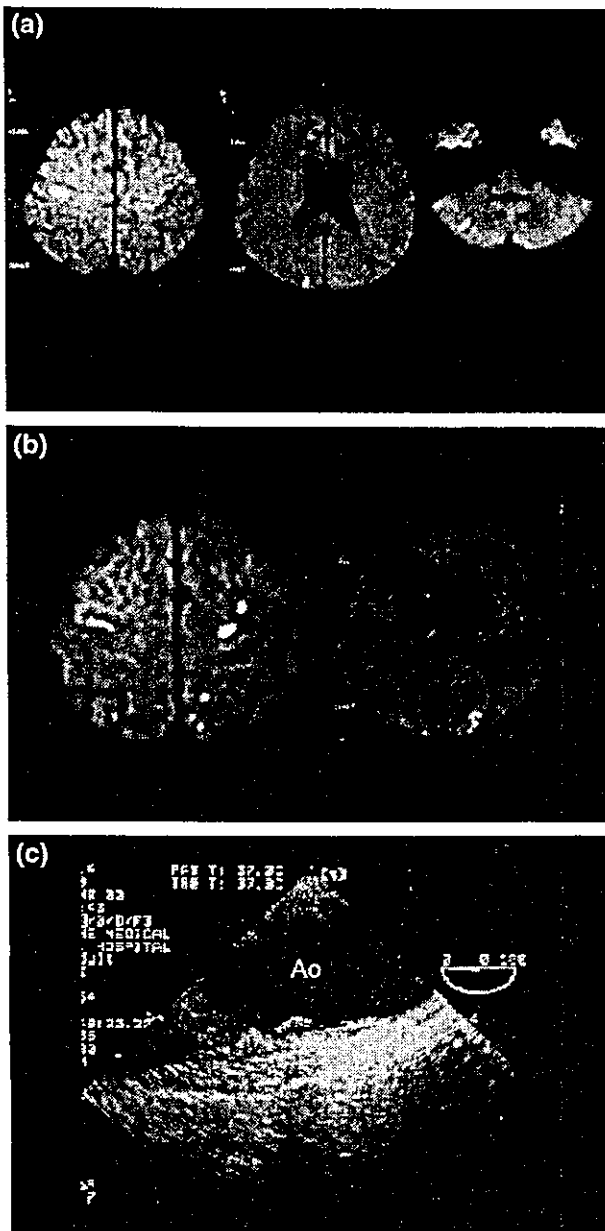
(a) The DWI of case 4. A 70-year-old man experienced paresis of left hand and was admitted to our hospital. DWI revealed small, high-intensity lesions in the right cortical branch of MCA and PCA territories and the right cerebellum. (b) DWI of case 4. Four months after initial admission, case 4 was readmitted to our hospital because of numbness in the left hand. DWI revealed multiple, small lesions in the anterior and posterior circulation territories bilaterally. (c) TEE in this case showed atheroma (\*) of ascending aorta. Ao: aorta.
